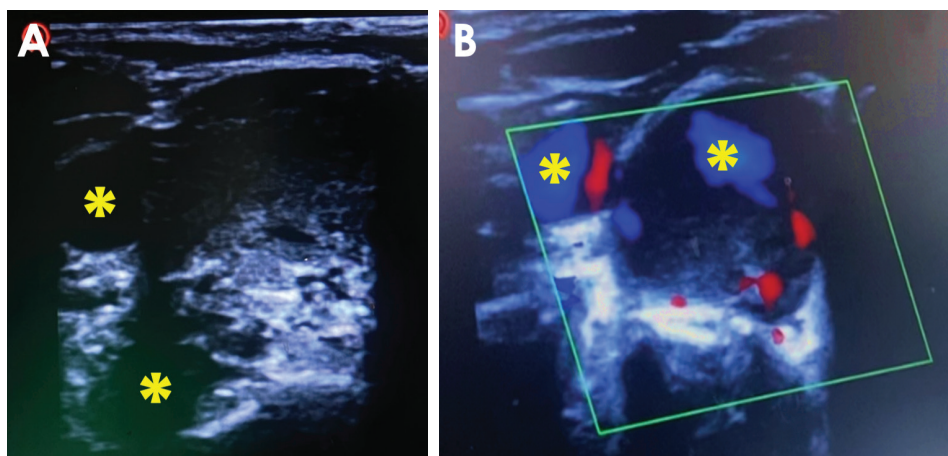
Ultrasound of the neck revealed hypoechoic solid lesions (*) in the superior and inferior segments of the right thyroid lobe with ill-defined margins (A & B), and minimal perivascularity noted (B).
